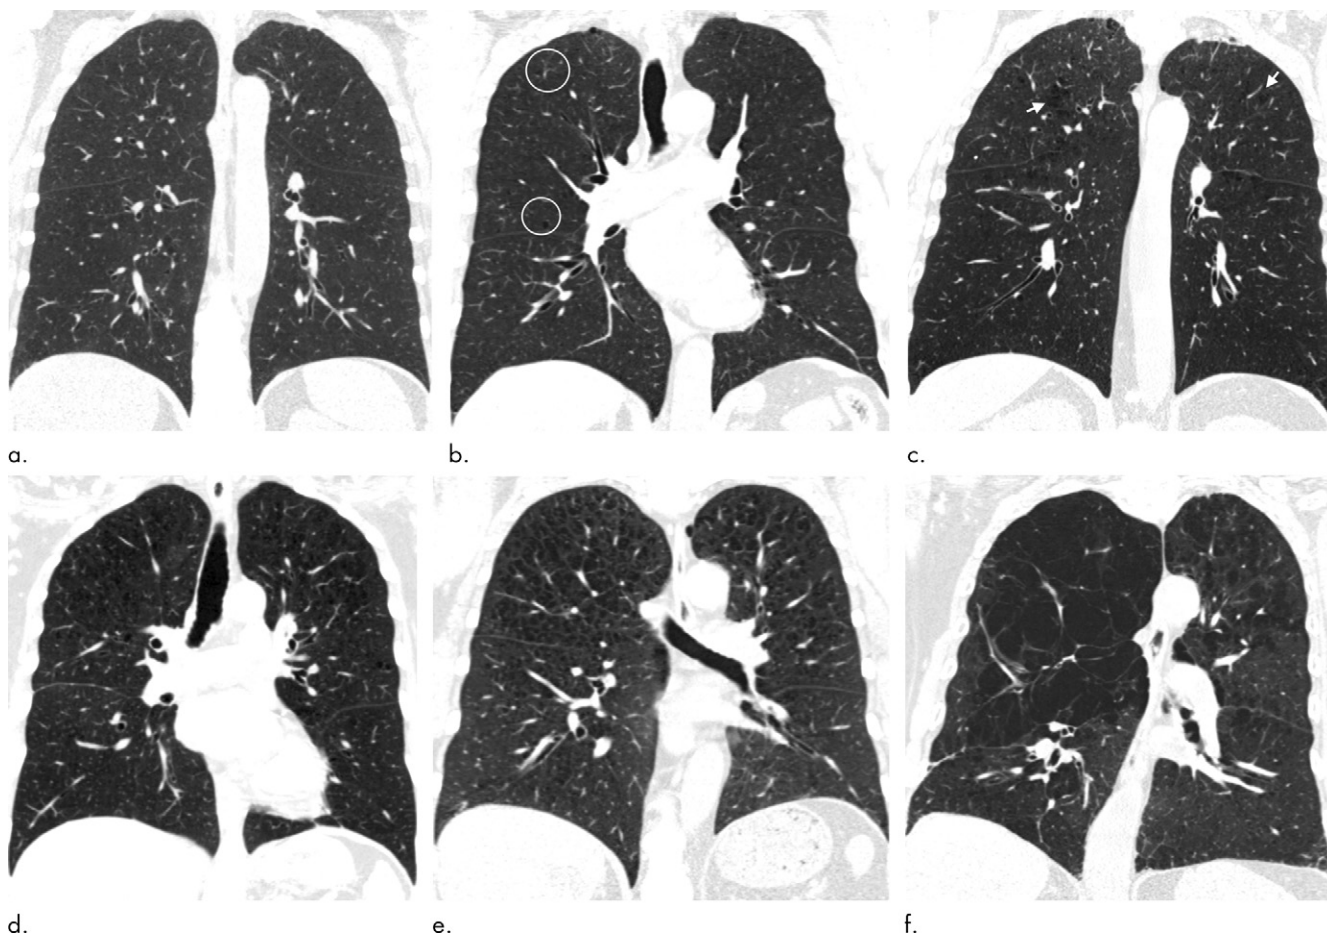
Coronal CT images show progressive grades of parenchymal emphysema on the basis of the Fleischner classification system. (a) Normal CT scan shows no emphysema. (b) Trace centrilobular emphysema (circles). (c) Mild centrilobular emphysema (arrows). (d) Moderate centrilobular emphysema involving more than 5% of the lung zone. (e) Confluent emphysema. (f) Advanced destructive emphysema.
